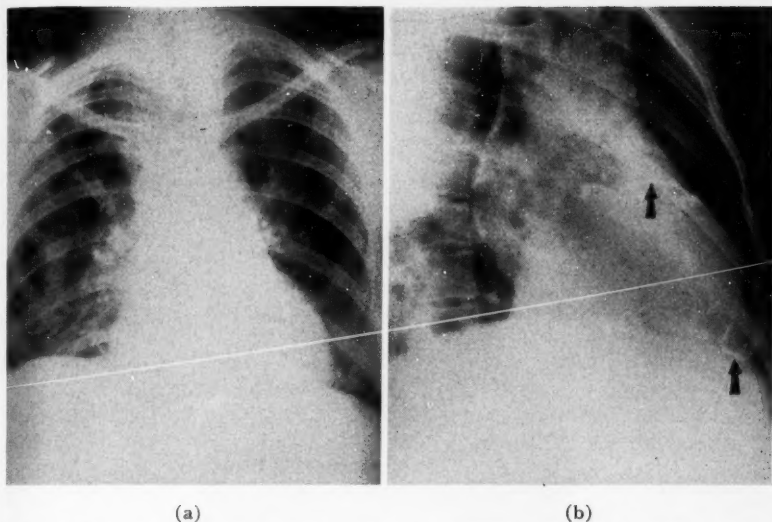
Extensive pericardial calcification poorly demonstrated on (a) routine posteroanterior roentgenogram, but well demonstrated in (b) right anterior oblique position, especially along sternal and diaphragmatic borders of right ventricle.
